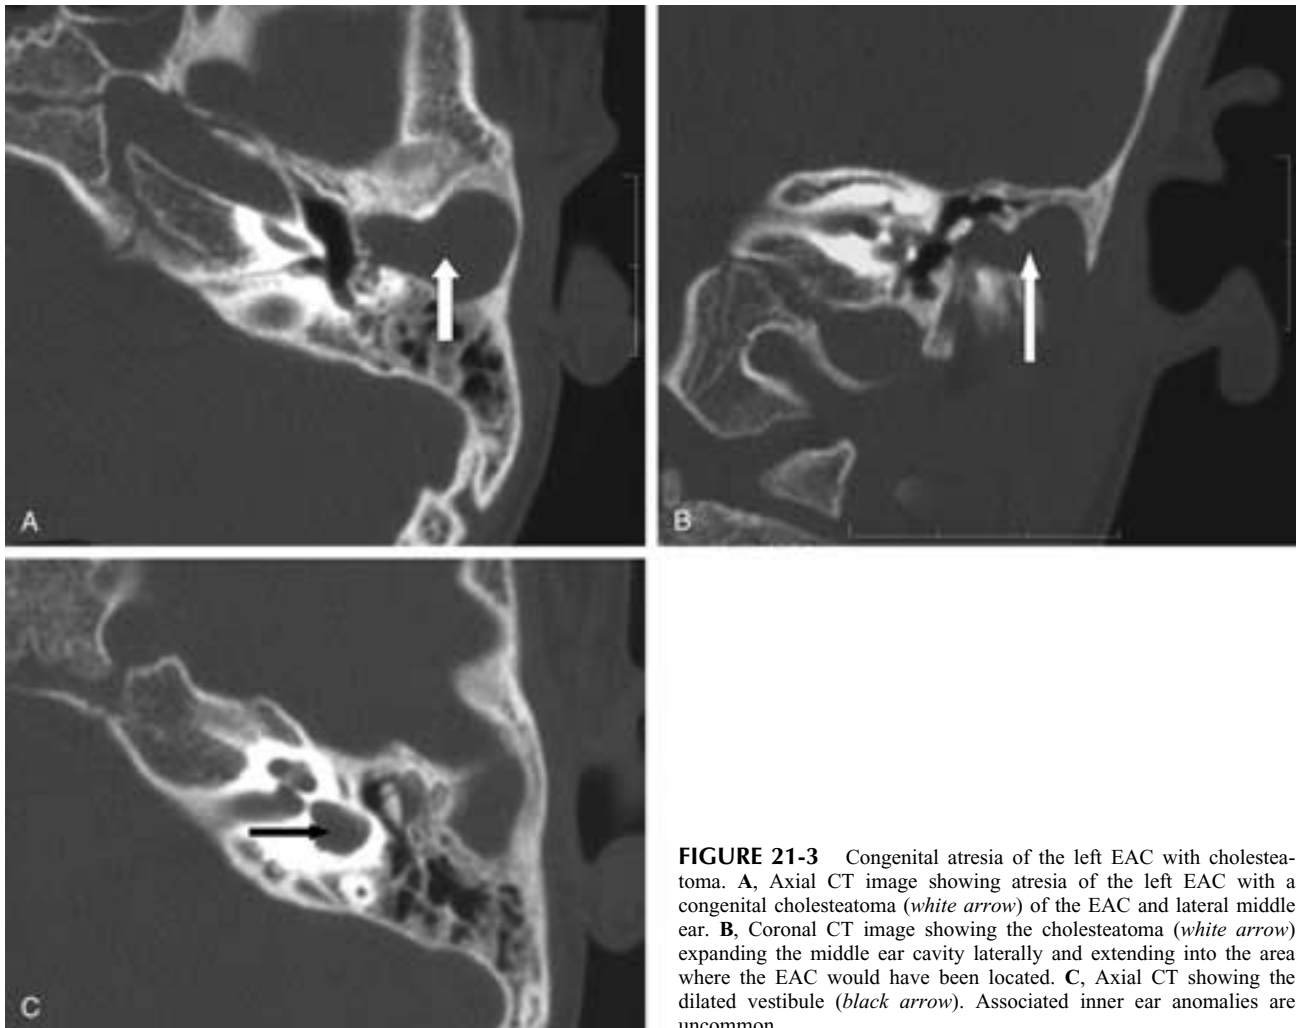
Congenital atresia of the left EAC with cholesteatoma. A, Axial CT image showing atresia of the left EAC with a congenital cholesteatoma (*white arrow*) of the EAC and lateral middle ear. B, Coronal CT image showing the cholesteatoma (*white arrow*) expanding the middle ear cavity laterally and extending into the area where the EAC would have been located. C, Axial CT showing the dilated vestibule (*black arrow*). Associated inner ear anomalies are uncommon.
